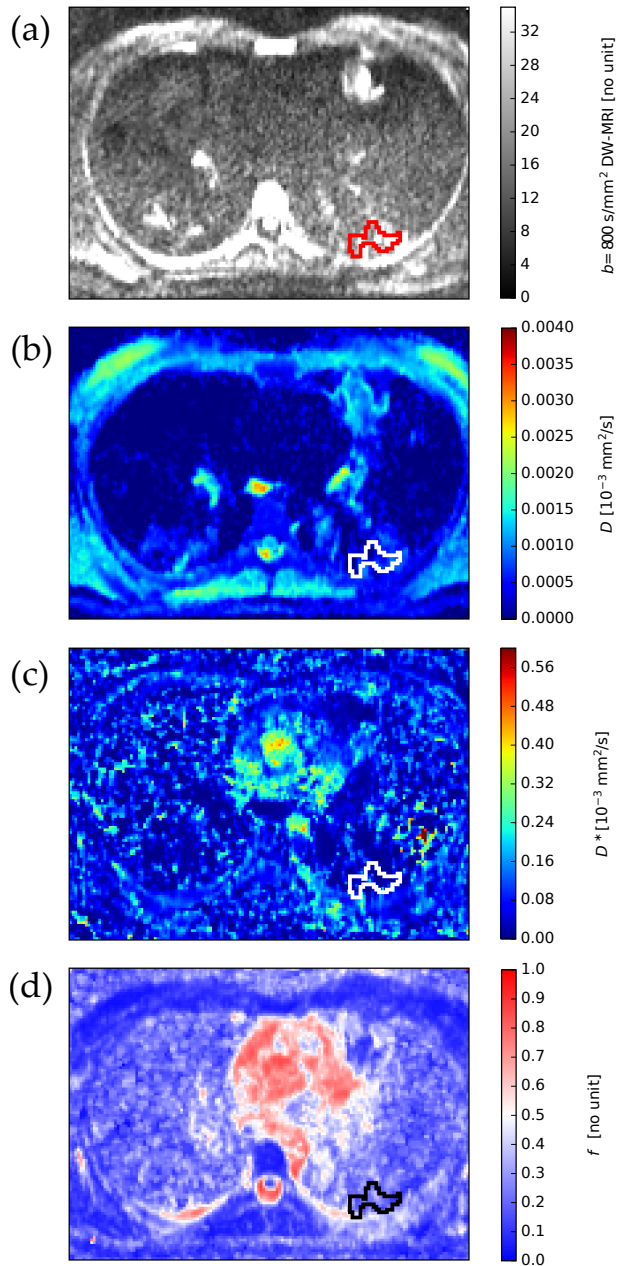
Examples of DW-MRI and fitted results. (a) $b = 800 \text{ s/mm}^2$ DW-MRI image with a VOI in the apical segment of the inferior left lobe, which was thereafter superimposed on the images, (b) D , (c) D^* and (d) f .
